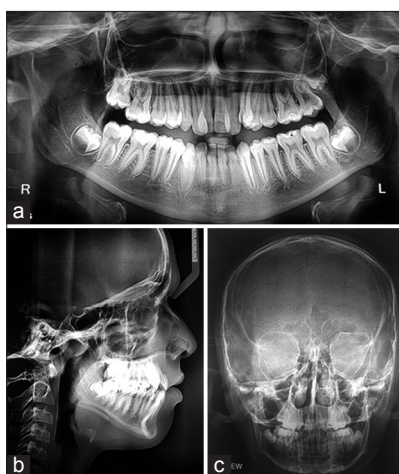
Pre-treatment radiograph, (a) Orthopantomogram, (b) Lateral cephalograph, (c) posteroanterior view
